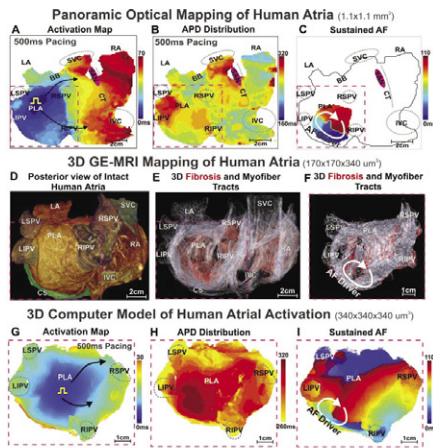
Structure and function of the explanted intact human atria. High-resolution panoramic optical mapping was conducted on the human heart activation map (A) and action potential duration (APD) map (B) during PLA pacing and reentrant AF driver (C). (D) A posterior view of the 3D human heart imaged by 9.4T GE-MRI at 170x170x340 μm³. 3D myofiber tracts (white) and fibrosis (red) for the whole atria (E) and LAFD (F). The structure and functionally-related computer model at an isotropic resolution of 340 μm was employed to fully capture activation pattern (G) and APD (H) during PLA pacing, and the reentrant AF driver (I). RA:LA: right:left atria; SVC: Bachmann's bundle; PLA: posterior left atrium; SVC: superior/inferior vena cava; SAN: sinoatrial node; CT: crista terminalis; LSP: LSP: left/right superior/inferior pulmonary vein.
